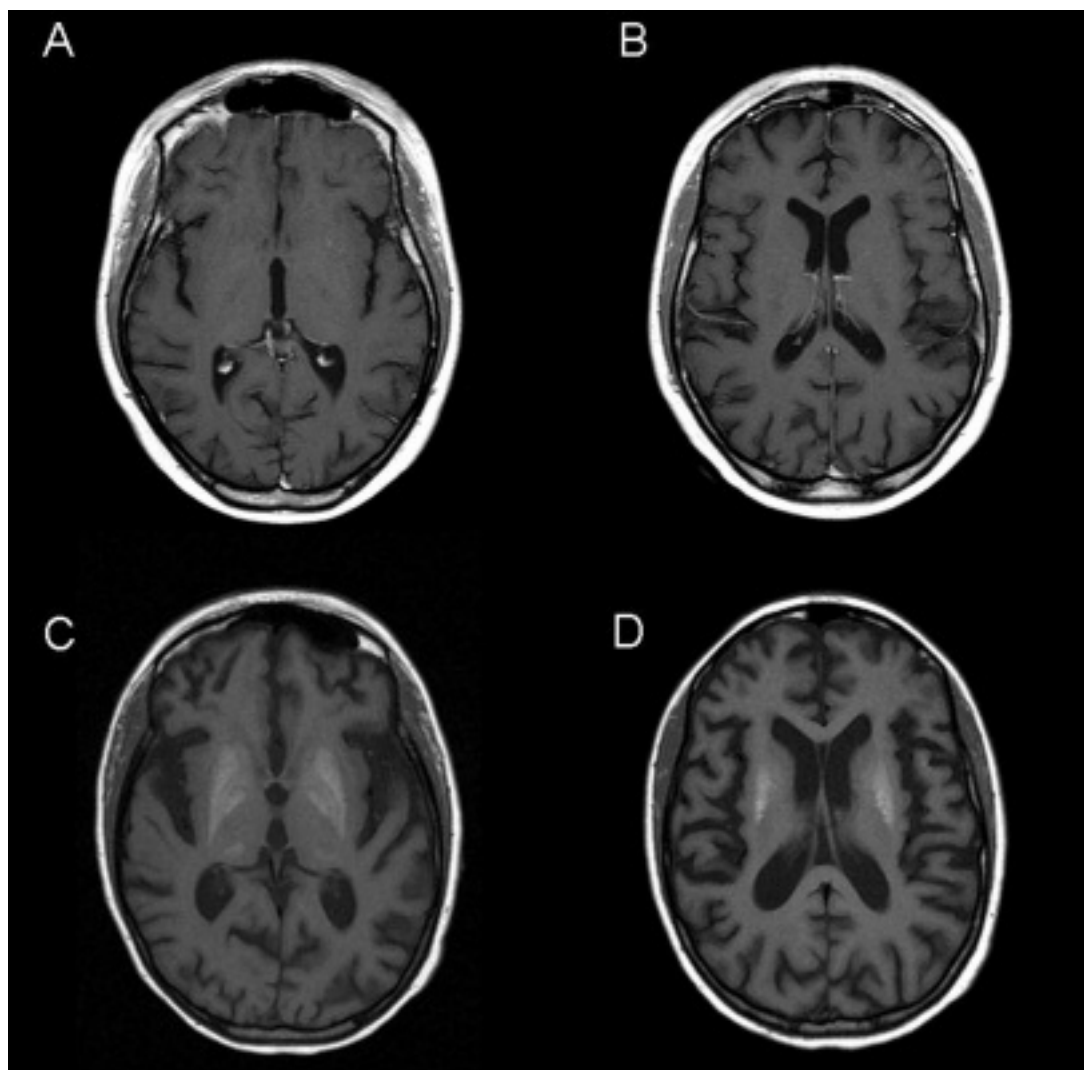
Qualitative assessment of moderate and severe cerebral volume loss. A. Axial T1-weighted image showing moderate dilatation of the third ventricle and cerebral sulci in a 14-year-old girl with protracted lupus disease course and presentation of acute confusional state and psychosis. B. Moderate dilatation of the supratentorial ventricular system in the same patient. C. Severe widening of the cerebral sulci and dilatation of third ventricle in a 20-year-old woman with protracted disease, multiple episodes of NPSLE, and recent lower extremity weakness. Note T1 bright signal in deep gray nuclei. D. Gross dilatation of bodies of lateral ventricles in association with widening of cerebral sulci in the same patient.
